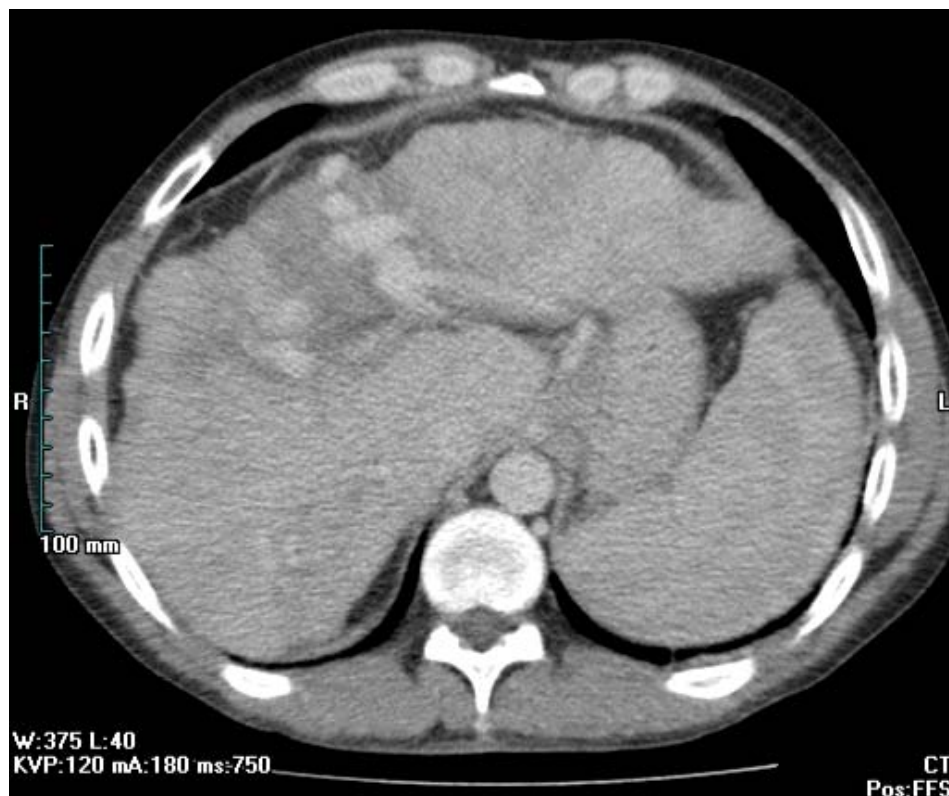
Contrast enhanced CT showing evidence of cirrhosis with nodular liver surface and also portal hypertension with a patent paraumbilical vein and spleen enlargement.
